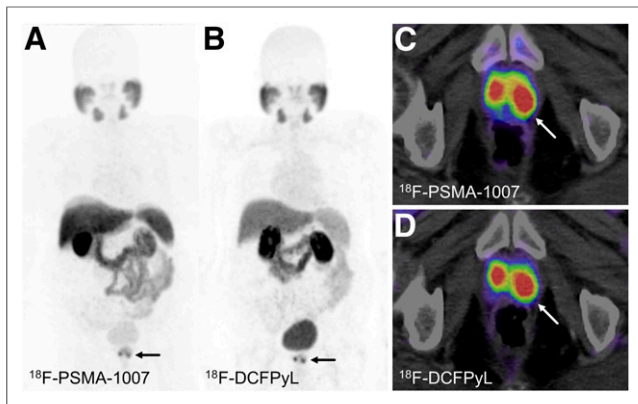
PET/CT images of 65-y-old patient referred because of Gleason score of 7a (3 + 4) and PSA serum level of 55.2 ng/mL. Patient was examined with ^{18}F -PSMA-1007 (A and C) and ^{18}F -DCFPyL (B and D). Images showed bifocal prostate cancer (arrows). Delineation of tumor growth in both lobes of prostate was possible with both tracers. SUV_{max} was 17.68 and 19.65 in right lobe and 14.21 and 16.60 in left lobe for ^{18}F -DCFPyL and ^{18}F -PSMA-1007, respectively.
